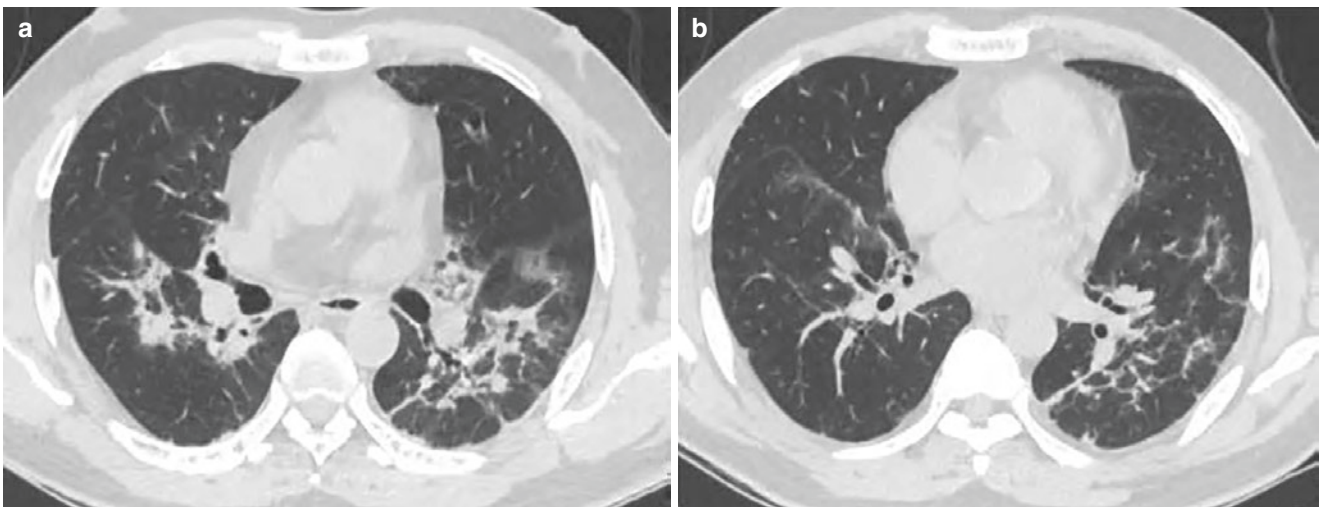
Organizing pneumonia caused by bleomycin. (a and b) CT lung window showed multiple asymmetric patchy lung consolidations around bronchi and subpleural
